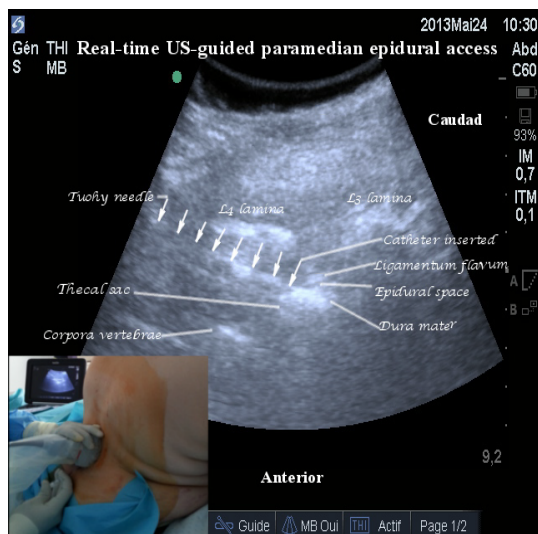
Paramedian oblique sagittal view: Tuohy needle and inserted catheter are visible on this sonogram.
